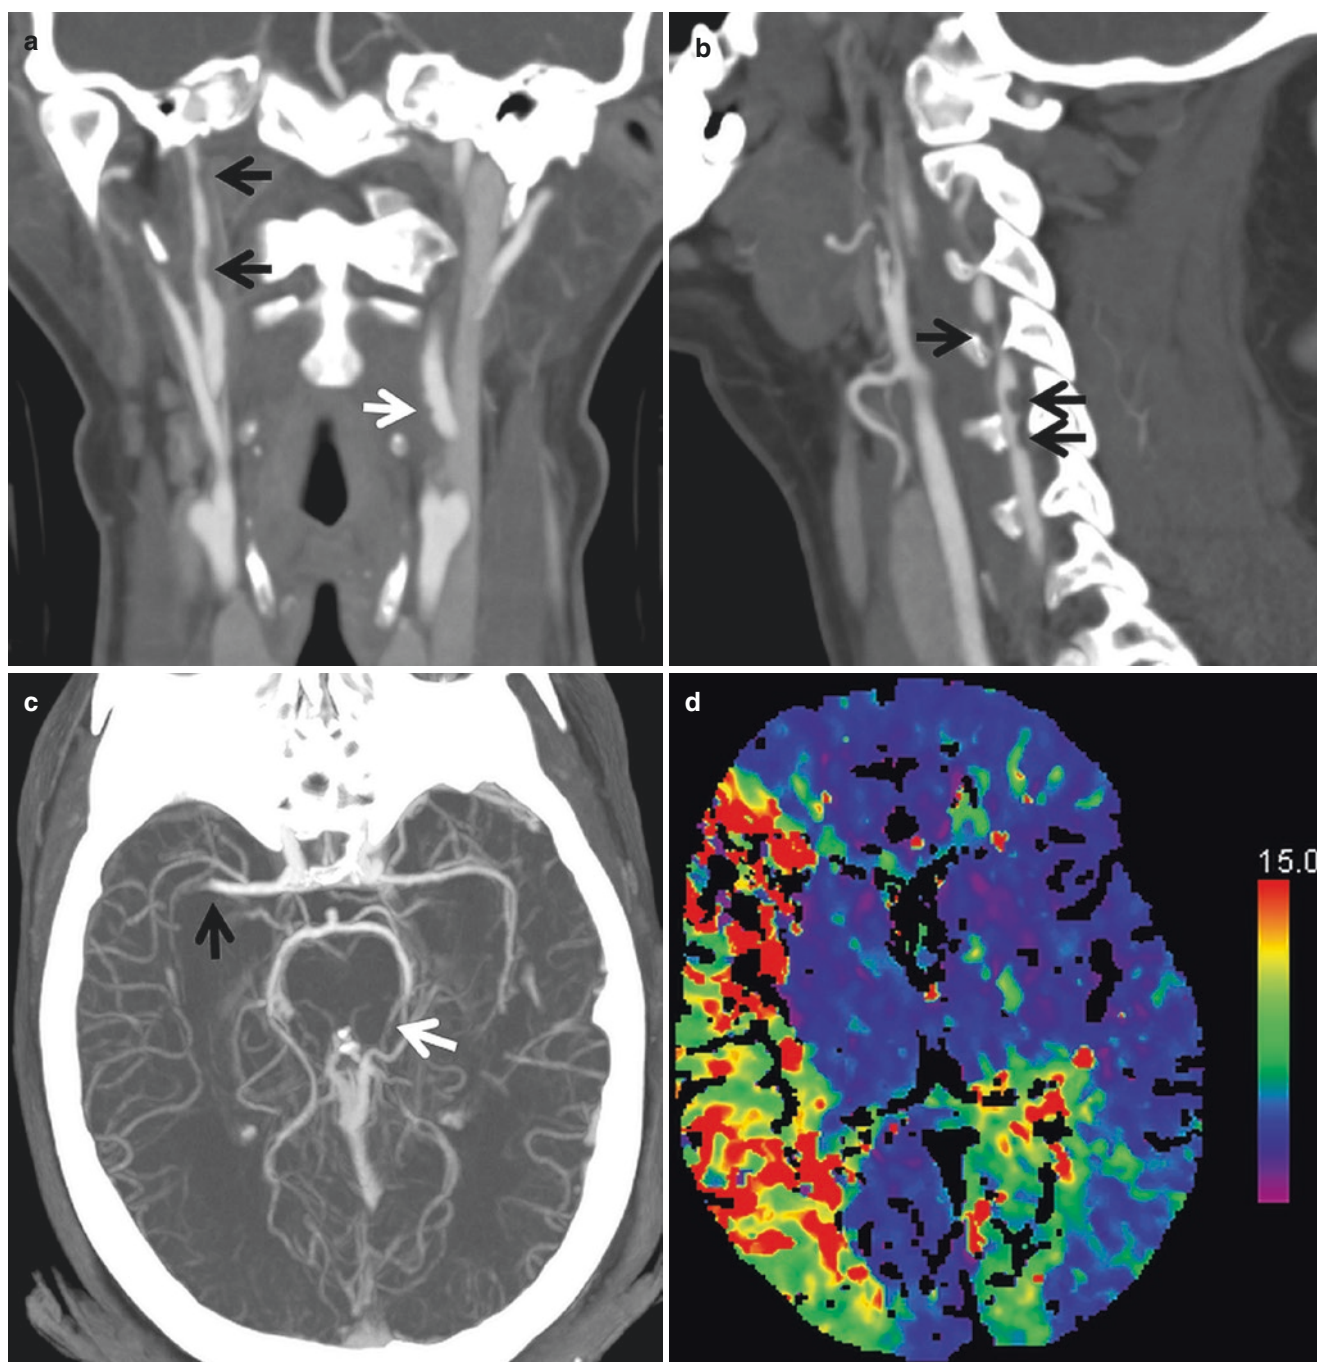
Multivessel injury with intracranial embolization. (a) Coronal reconstructed CTA of patient with motor vehicle collision demonstrates grade II injury of right ICA (*black arrows*). Also note additional grade I injury of the left ICA (*white arrow*). (b) Multifocal grade II injury of left vertebral artery on the sagittal reconstructed image. (c) Intracranially, there is abrupt occlusion of right MCA (*black arrow*) and left PCA
